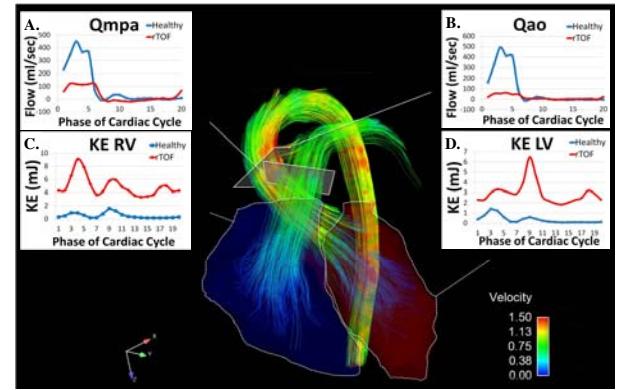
4D Flow MRI was used to calculate flow and KE. [A-B] Flow in main pulmonary artery (mpa) and Aorta (ao) during a cardiac cycle in a sample healthy volunteer and rTOF. [C-D] KE_{RV} and KE_{LV} in the same healthy volunteer and rTOF. Note the high KE and low Qao and Qmpa of the rTOF patient.
